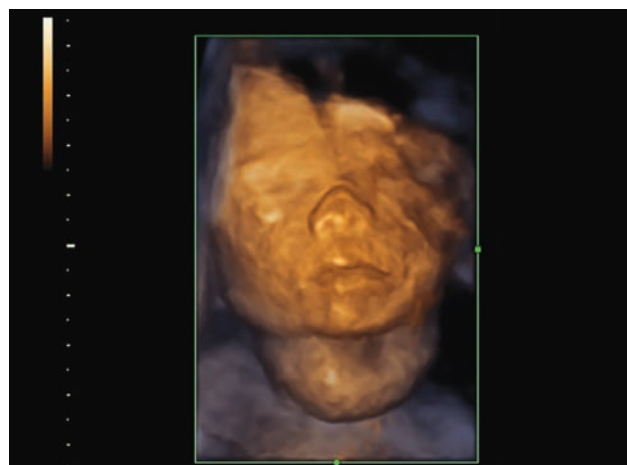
Three-dimensional sonography of the face and fetal neck
